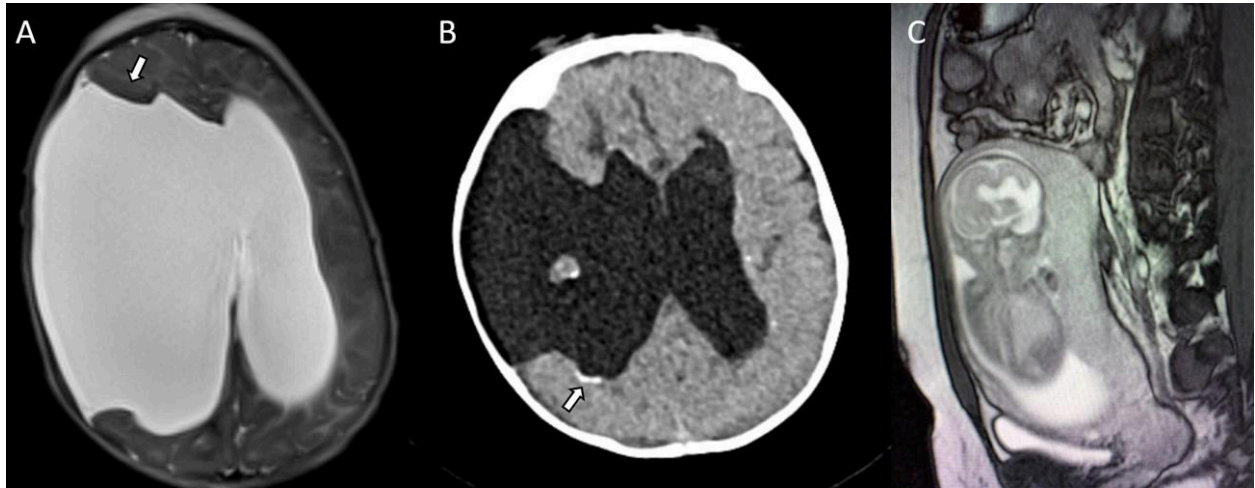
Schizencephaly in *COL4A1* variants. (A) Axial T2 image shows a large right-sided schizencephaly, see abnormal gray matter lining (arrow), case 1 at 3 months old. (B) CT shows large right-sided schizencephaly with surrounding calcification (arrow), case 13 at 15 weeks old. (C) Fetal MRI of same patient (B) shows schizencephaly.
